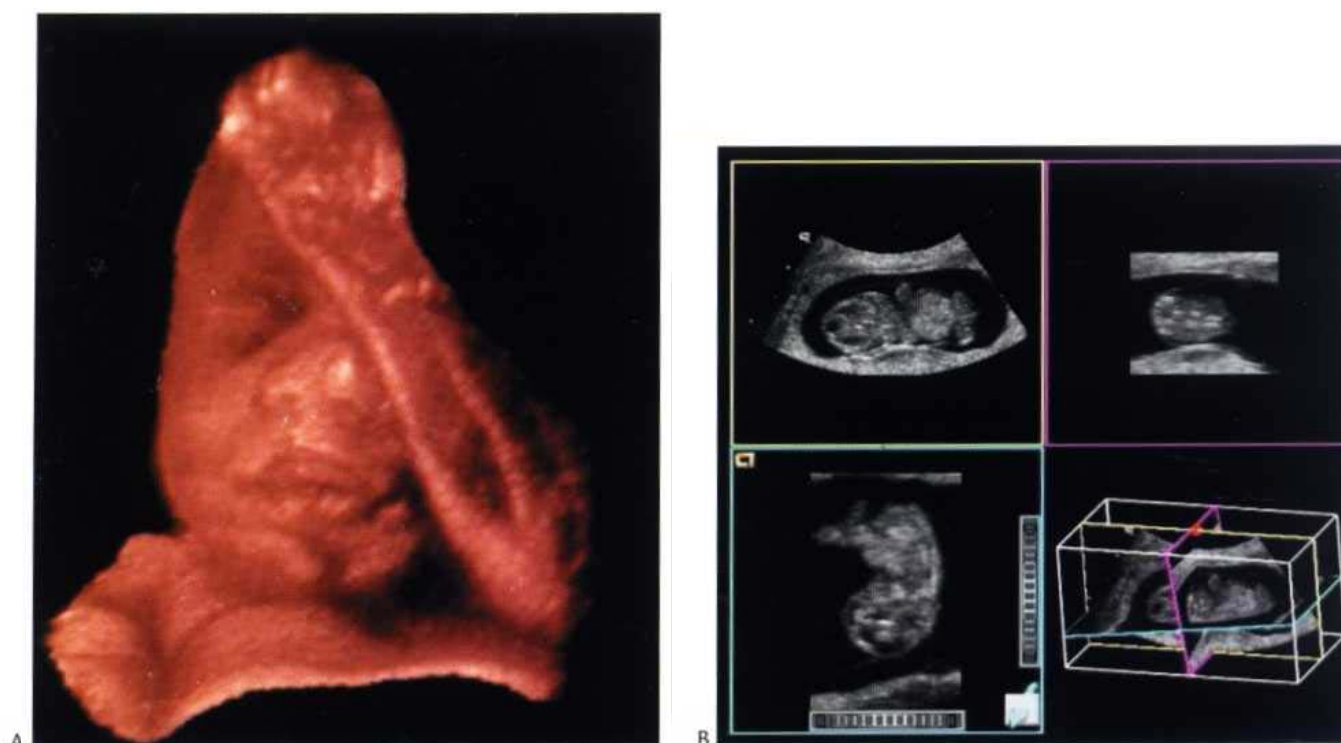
3D ultrasound. (A) shows a reconstruction of a fetal face and arm; (B) shows planar reconstructions from the data volume shown at the bottom right. (Courtesy of Acuson.)
